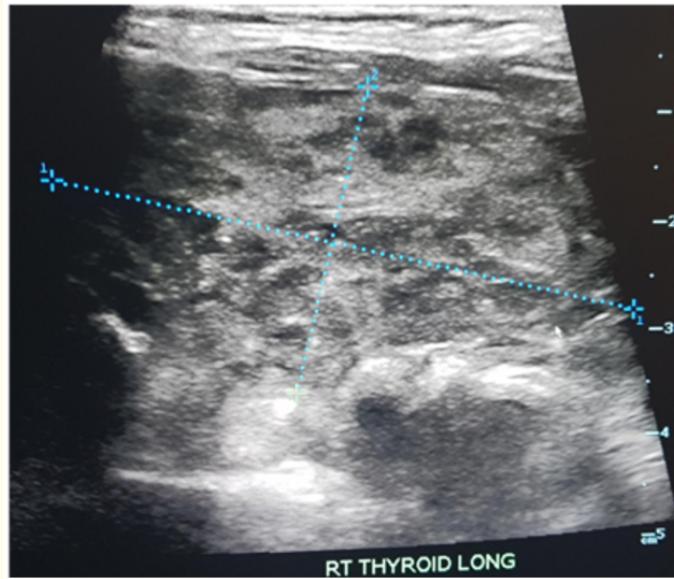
Ultrasound of the right thyroid long axis which showed heterogeneous enlargement of the right thyroid gland.
